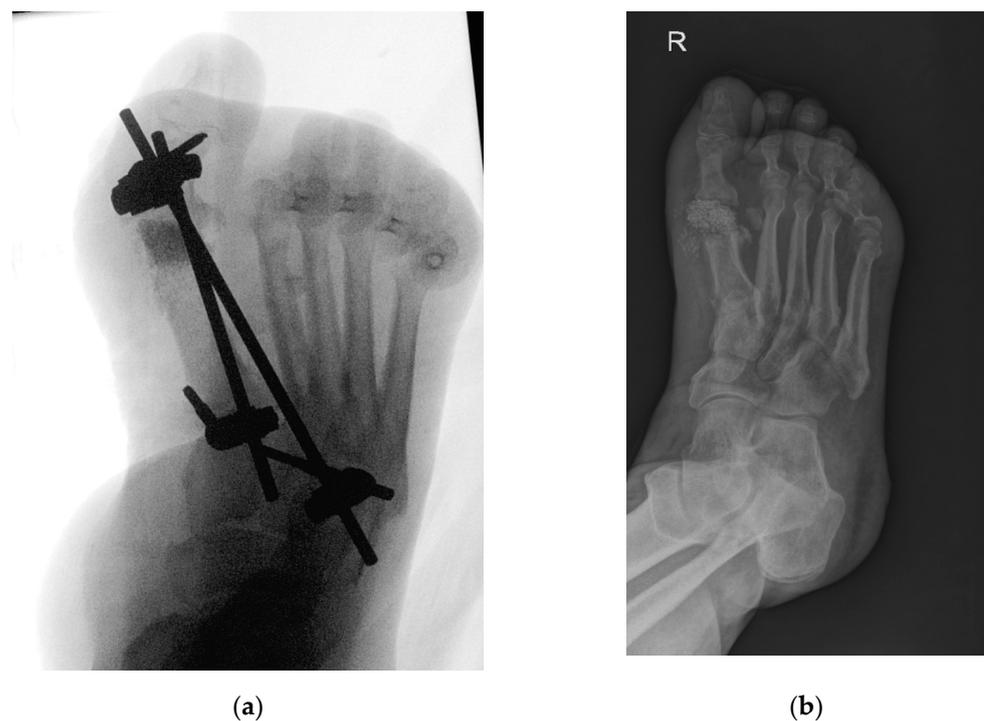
(a) Intraoperative X-ray—resection of 1st metatarsophalangeal joint, placement of bioactive glass granules, and placement of external fixation device. Image captured intraoperatively with diascopy using Siemens Cios Alpha[®] (Siemens, Munich, Germany) (average exposition parameters: 50 kV, 0.05 mAs, and 5 fps); (b) patient three months after resection of 1st metatarsophalangeal joint and bioactive glass insertion. Image captured with Philips Digital Diagnost[®] (Philips, Amsterdam, The Netherlands) (exposure parameters: 70 kV and 2 mAs).
